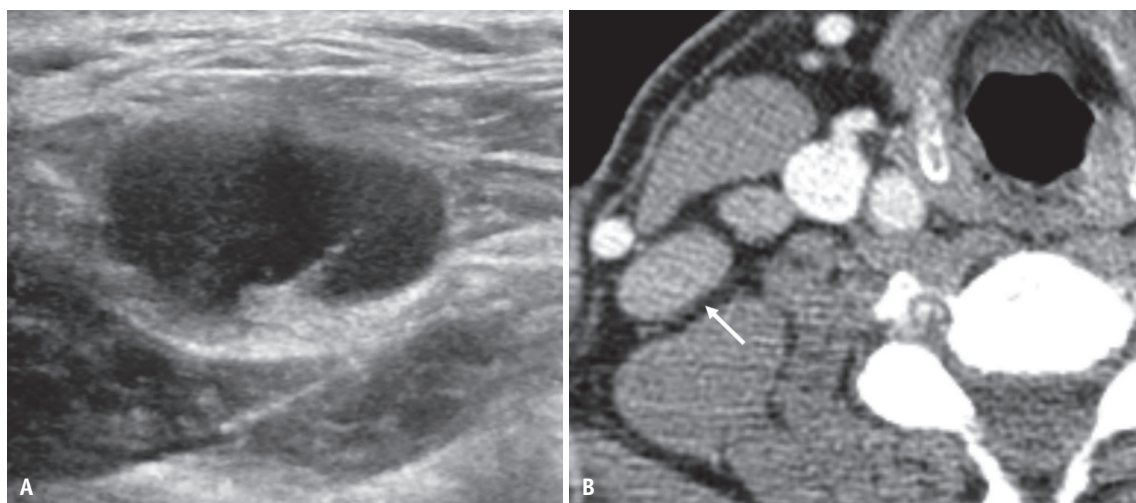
A 79-year-old female with right papillary thyroid carcinoma. An enlarged lymph node (10 mm in short diameter) at the right level II with right papillary thyroid carcinoma showing a LN with a preserved echogenic hilum, which was classified as probably benign on US (A). This LN shows loss of the hilum (arrow) on axial contrast-enhanced CT (B) and is classified as indeterminate. Core needle biopsy confirmed a benign hyperplastic lymph node. CT = computed tomography, US = ultrasound, LN = lymph node
